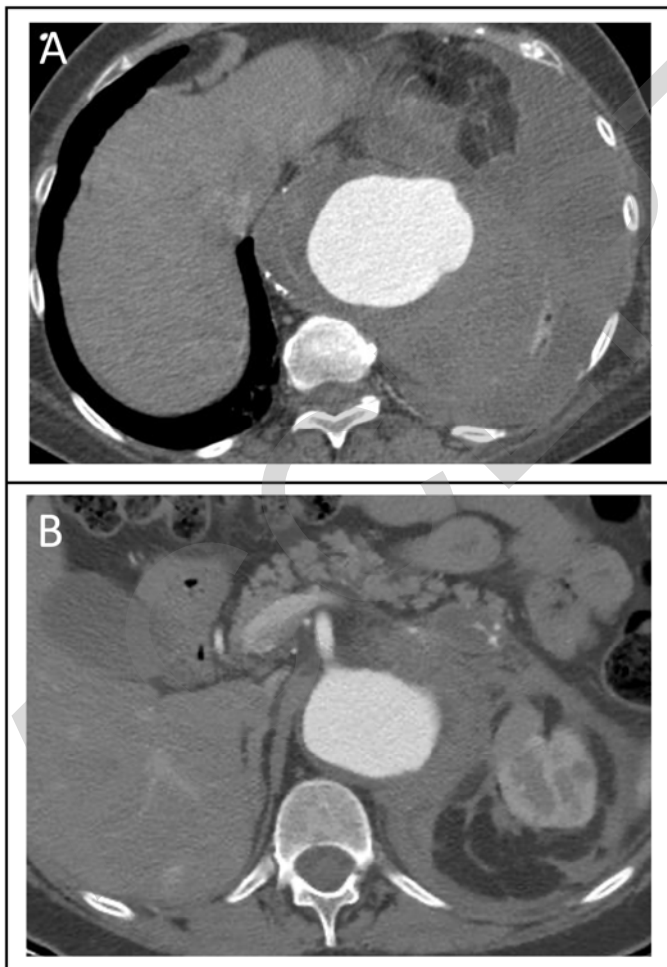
Examples of preoperative computed tomography angiography (CTA), preoperative three-dimension volume rendering (3D VR) and post-operative 3D VR of ruptured thoraco-abdominal aortic aneurysms (r-TAAA) cases repaired using off-the shelf (A), custom-made (B) and physician modified endograft (C) techniques.
